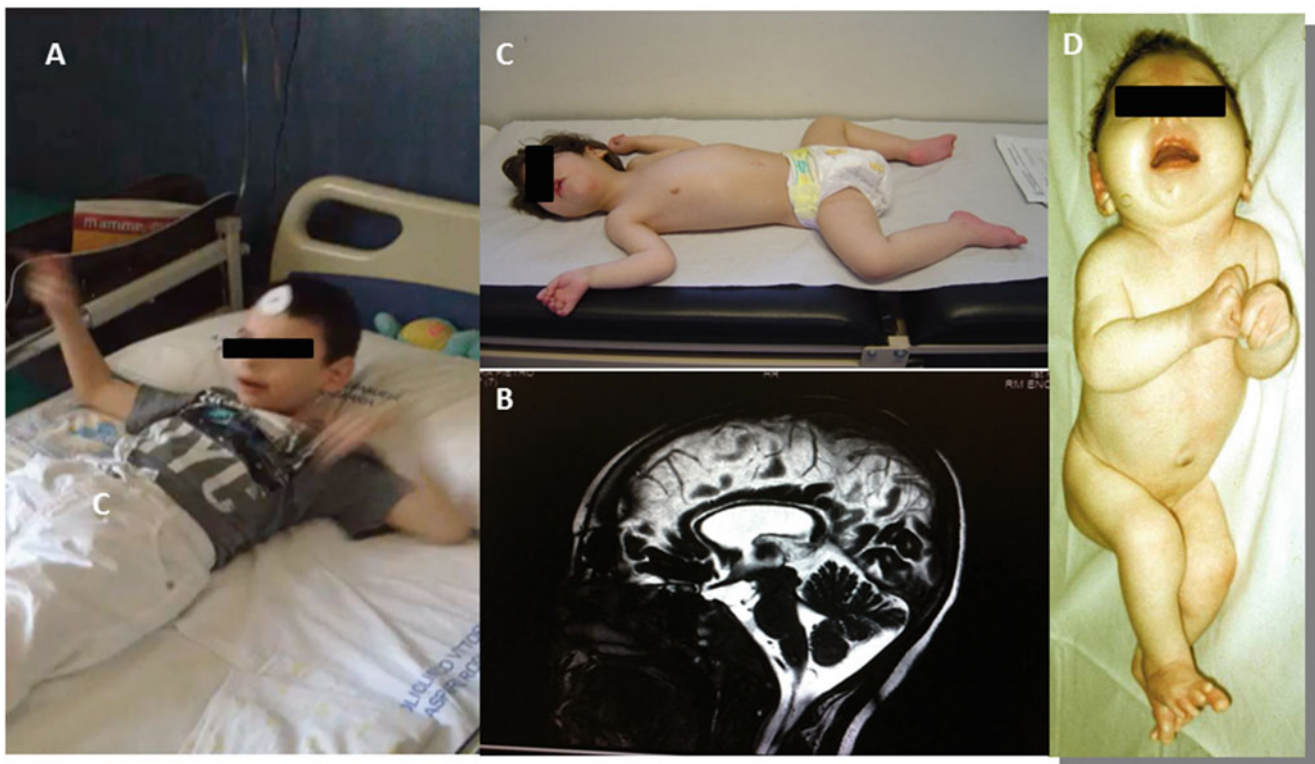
Clinical and neuroimaging features of present patients with CDG and EOEE. (a) Case # 1 ALG6-CDG. (b) Case #1 MRI showing thin corpus callosum. (c) Case # 2 DPM2-CDG. (d) Case # 3 ALG3-CDG
